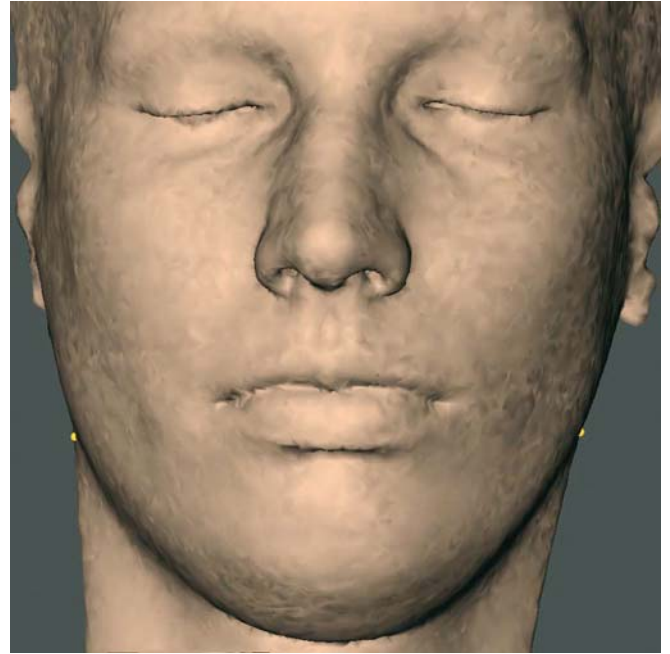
Soft tissue gonion_r and soft tissue gonion_l. Frontal view (3-D CT, patient K.C.)
